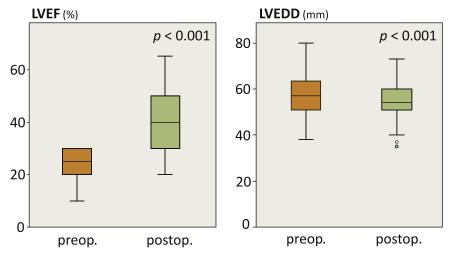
Left ventricular ejection fraction (*LVEF*) and left ventricular end diastolic diameter (*LVEDD*) preoperatively and before discharge from hospital as assessed by echocardiography. *preop*, Preoperatively; *postop*, postoperatively.
